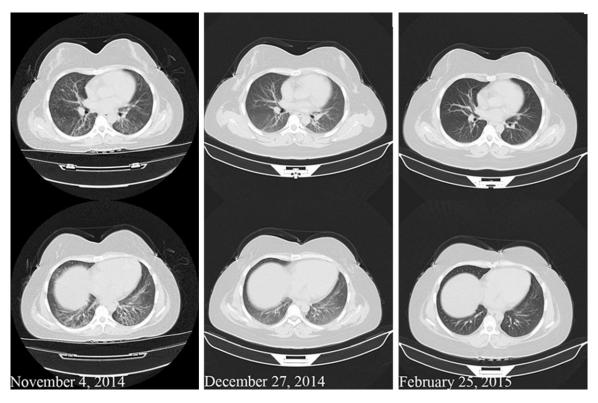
CT scan of the chest of the second case. On admission, diffuse ground glass, many patchy and consolidations along Bronchial blood vessel bundle with bilateral lower lobes predominance on November 4, 2014. Bilateral ground-glass consolidations evidently reduced on December 27, 2014 and February 25, 2015.
